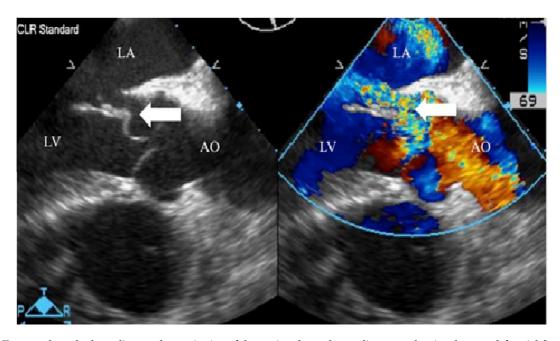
Transesophageal echocardiogram, long axis view of the aortic valve and ascending aorta showing the aorto-left atrial fistula (arrow) with and without color Doppler views. AO = aorta; LA = left atrium; LV = left ventricle.
